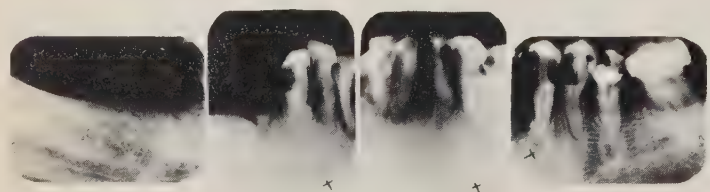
Radiation caries as depicted radiographically.
